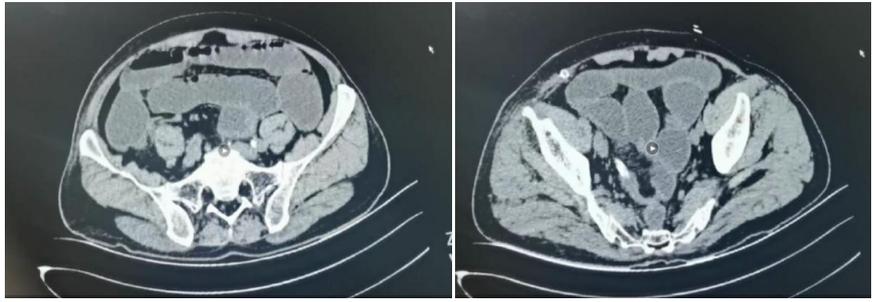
Abdominal CT image on the seventh day after rectal cancer surgery.
